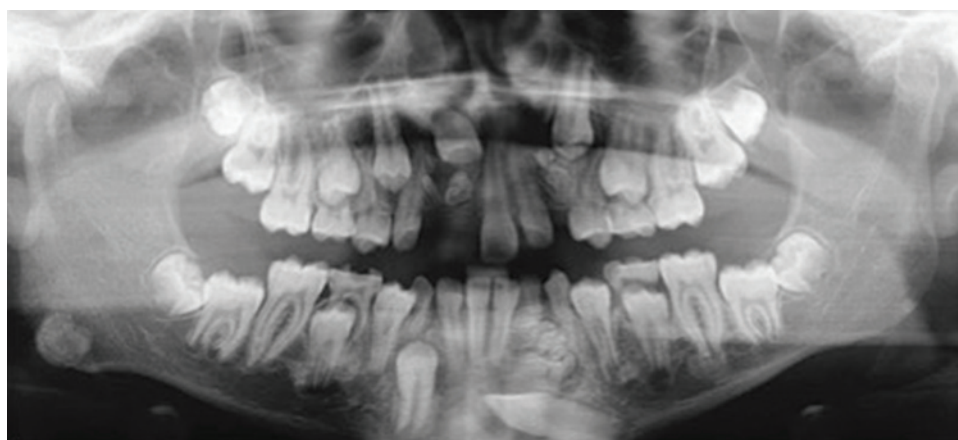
Panoramic radiograph demonstrating adolescent patient with a right mandibular osteoma, multiple odontomas, and impacted teeth.
